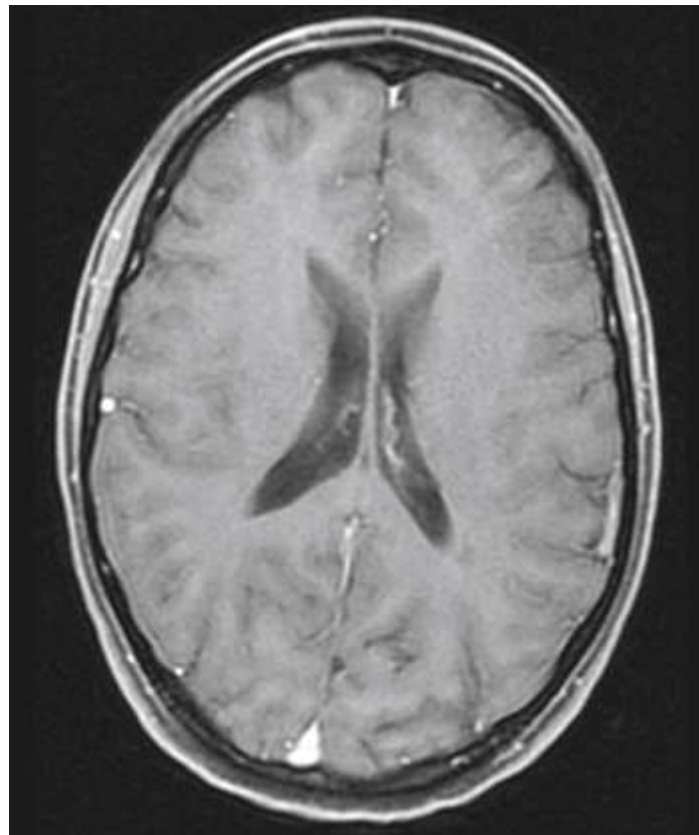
MRI corresponding to level *B* in Fig. 24.5B.
